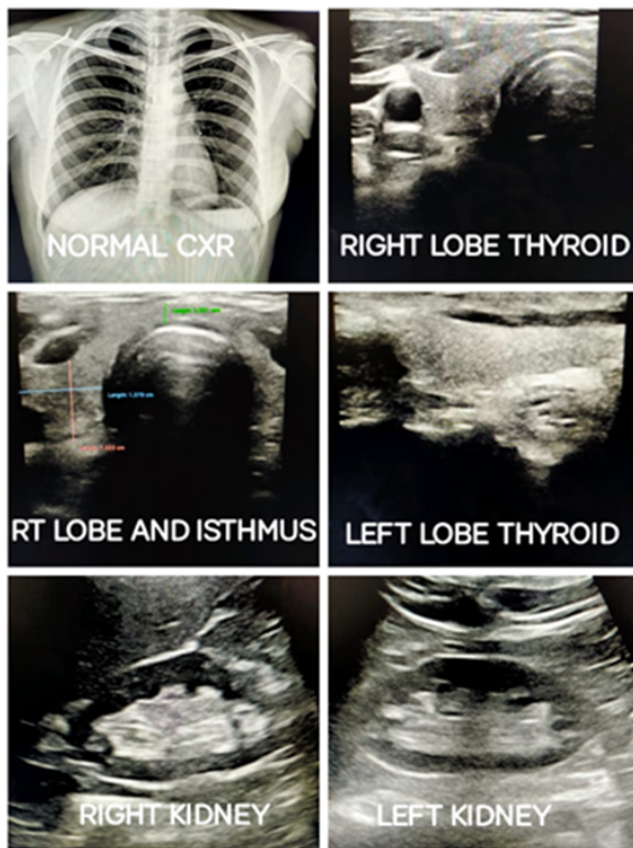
Normal chest radiograph of PA view, Normal ultrasound of both kidneys and thyroid
